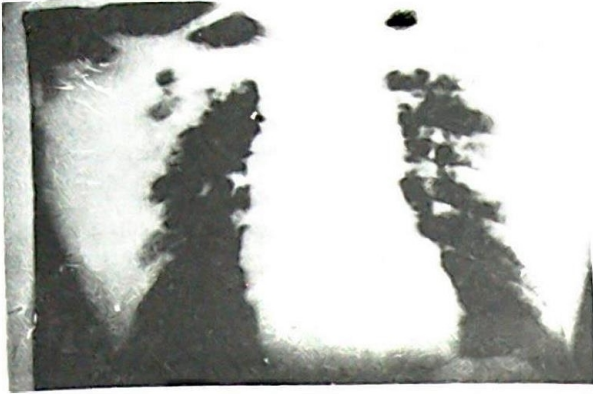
Chest x-ray of 45 year old male subject with affection of all the lung zones.
